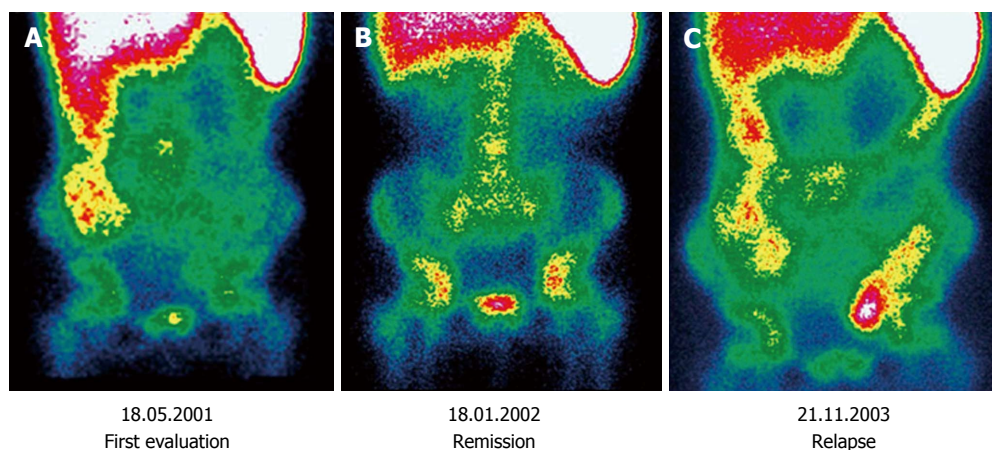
Three sequential ^{99m}Tc -HMPAO-white blood cell scintigraphies performed in a patient diagnosed with Crohn's disease. A: Performed at diagnosis, there is evidence of increased activity involving colon ascendens; B: Performed at follow-up after immunological therapy, a complete remission can be demonstrated; C: There is evidence of a relapse involving colon ascendens and sigma-rectum. Reprinted with permission of Springer Verlag from Caobelli *et al.*^[34]
